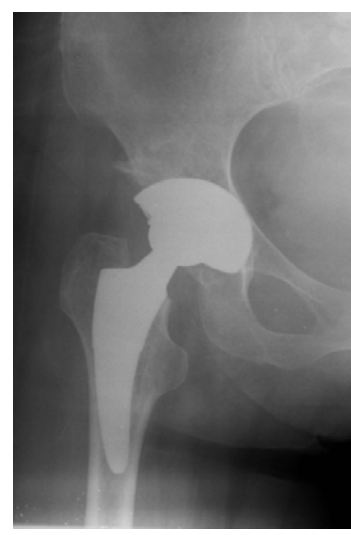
Right hip radiograph twenty-four months after the surgery.
